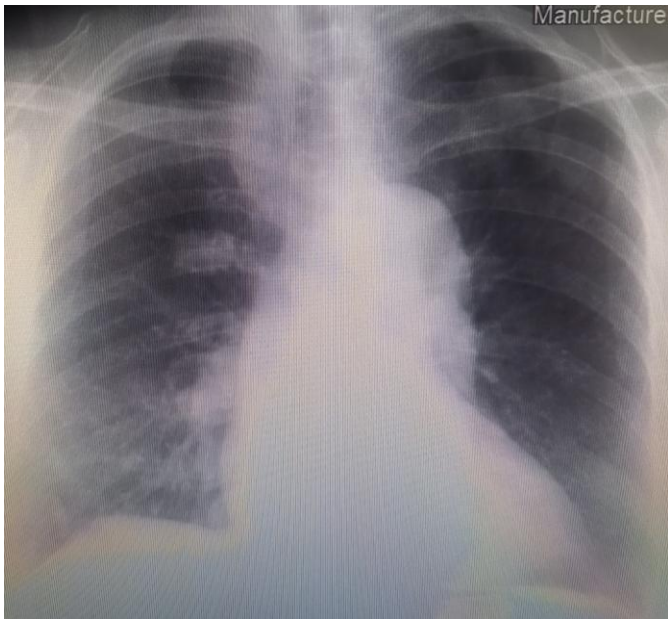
Preoperative chest X-ray. Right lung nodule with a smooth outline.
